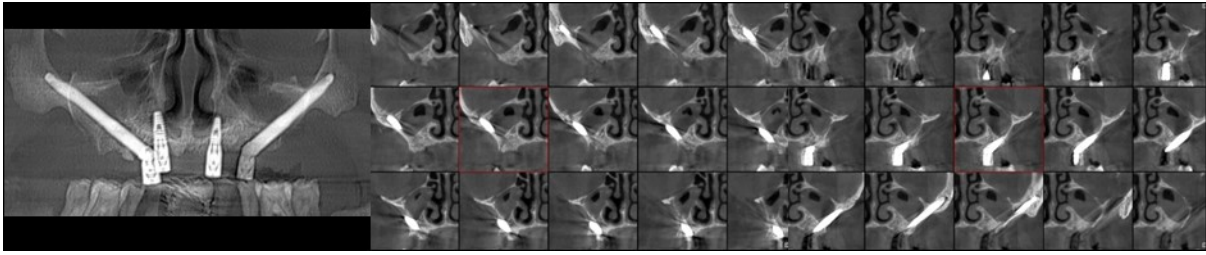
Final computed tomography with coronal and cross sections
